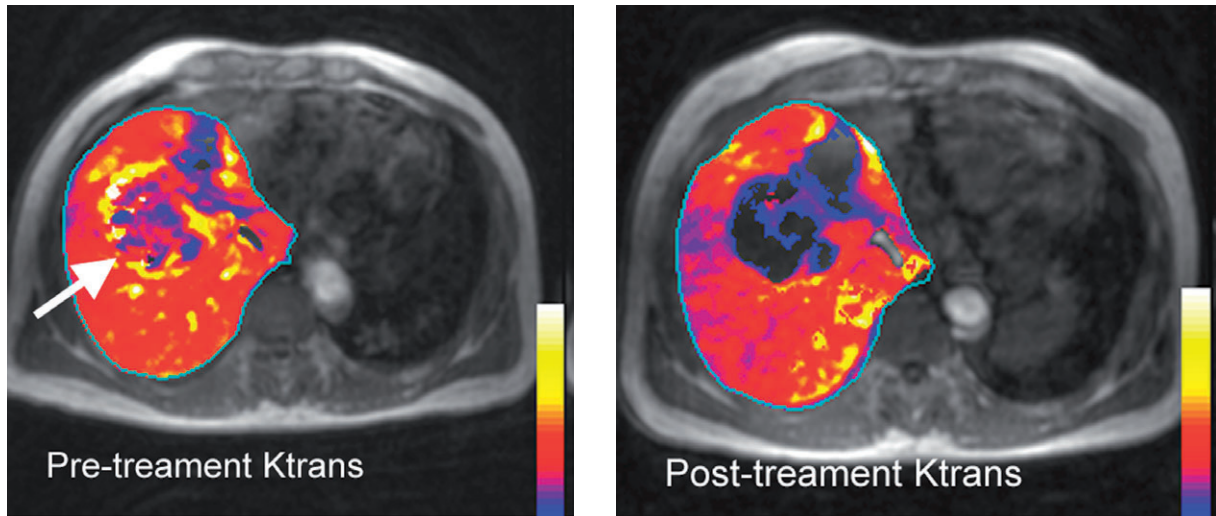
Maps of vascular parameter *Ktrans* obtained using DCE-MRI before and after vascular targeted therapy. These maps were created by overlaying the quantitative vascular parameter *Ktrans* (in colour) on the morphological T1-weighted images. Left: prior to treatment, the liver metastasis (arrow) showed an increase in *Ktrans*, particular at the tumour rim. Right: the *Ktrans* was substantially reduced at 14 days after the initiation of vascular targeted treatment.
